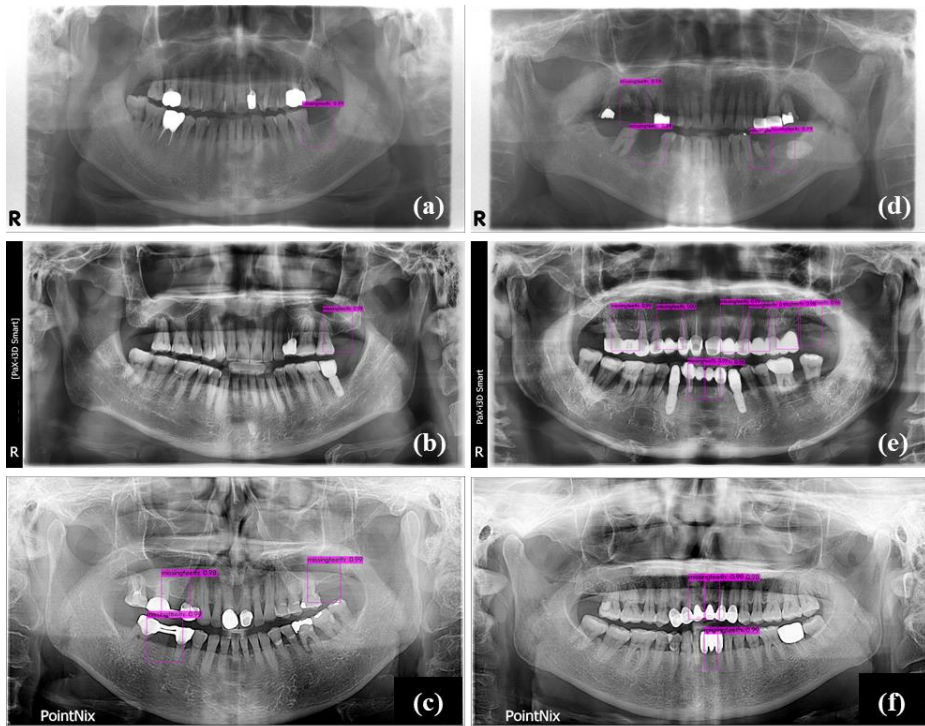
The detection results for the missing teeth by the CNNv4-tiny using dental panoramic radiographs acquired from multiple devices. The detected bounding boxes of the locations of the missing teeth were superimposed on the input images for type 1 (a-c) and type 2 (d-f). The first, second, and third rows are the images from the device 1, device 2, and device 3, respectively.
